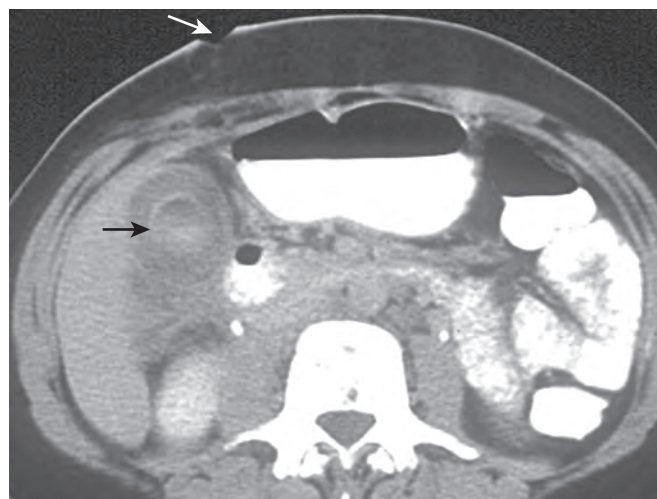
Trauma to gallbladder. CT 2 days after stab wound to the right upper quadrant shows gallbladder wall thickening with an intraluminal bile-blood level and infiltration of the pericholecystic tissue (black arrow). A subcutaneous right upper quadrant defect (white arrow) indicates the location of the penetrating knife. At surgery, two lacerations were found in the anterior and posterior aspect of the gallbladder with mild biliary peritonitis. (From Zissin R, Osadchy A, Shapiro-Feinberg M, et al: CT of a thickened-wall gall-bladder. *Br J Radiol* 76:137-143, 2003.)
